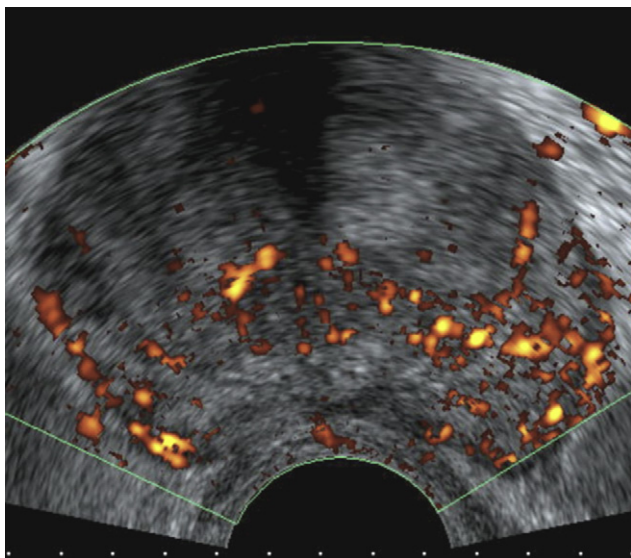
Acute prostatitis. Endorectal power Doppler sonogram of the prostate (examination not indicated in the first 24 hours or in patients who respond well to treatment): hypervascular focal point in the left posterior peripheral zone.
